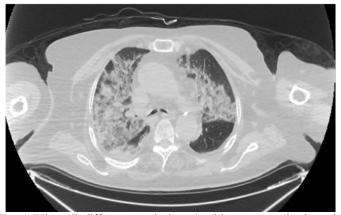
Bilaterall diffuse ground glass densities are seen in the axial section of the patient's thoracic computed tomography
